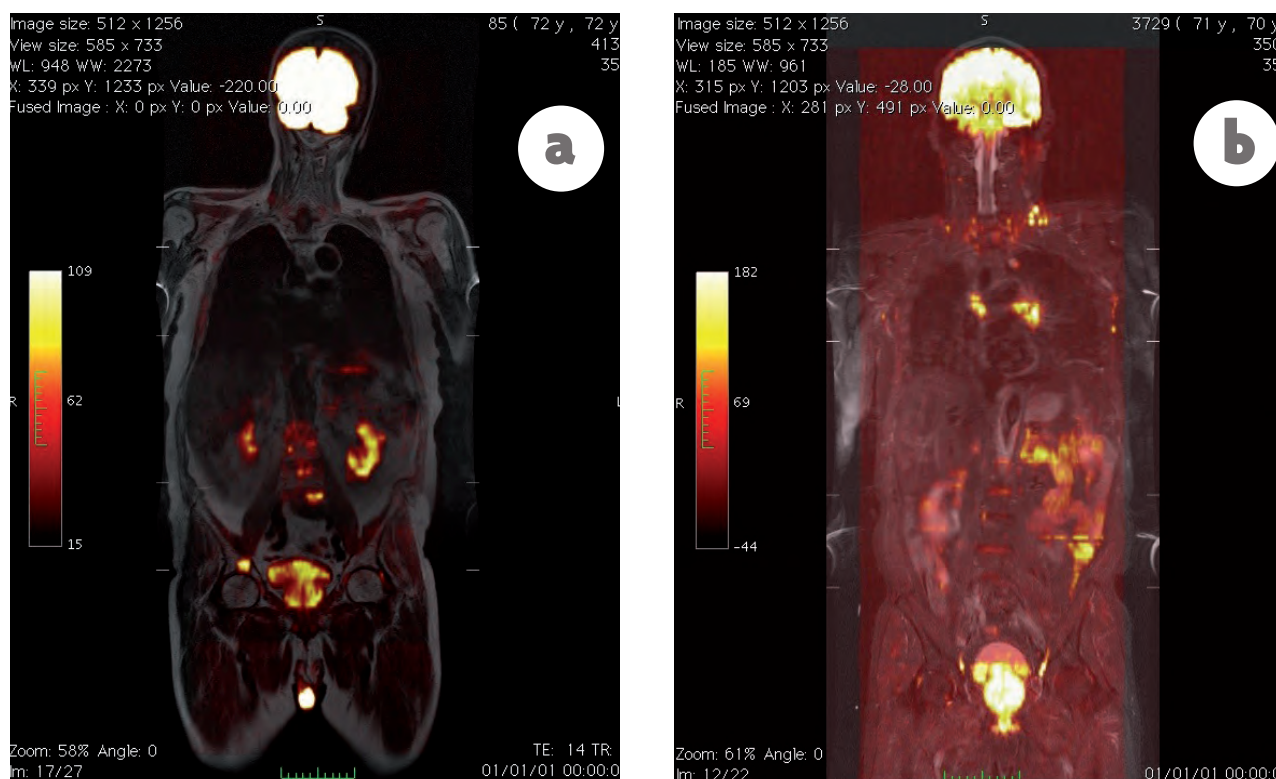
(a) Whole-body coronal T1-weighted image combined with coronal DWI b-600 (hot iron color) at 1.5T; (b) Whole-body coronal STIR combined with coronal DWI of the same patient at 1.5T
